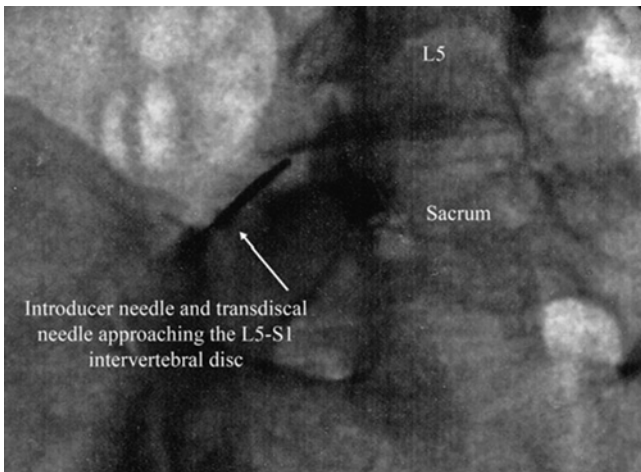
Oblique radiographic view of transdiscal needle
